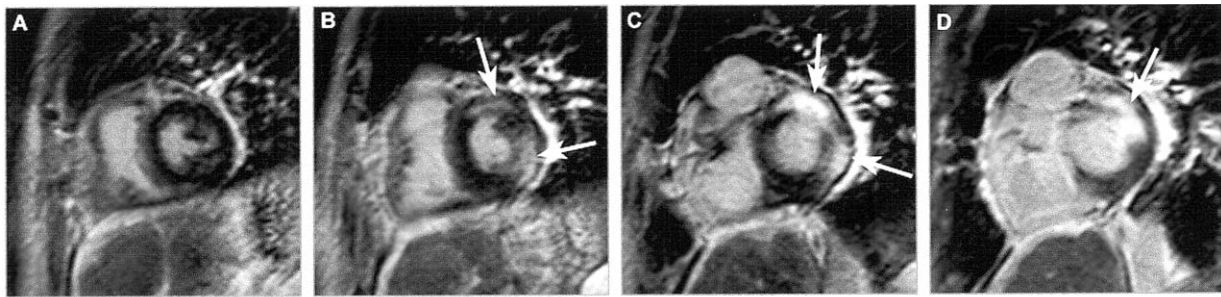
DE-MRI short-axis images extending from the level of the mid ventricle (A) toward the base of the heart (B–D) show hyperenhancement consistent with sarcoid infiltration of the left ventricular anterolateral base (arrows).
